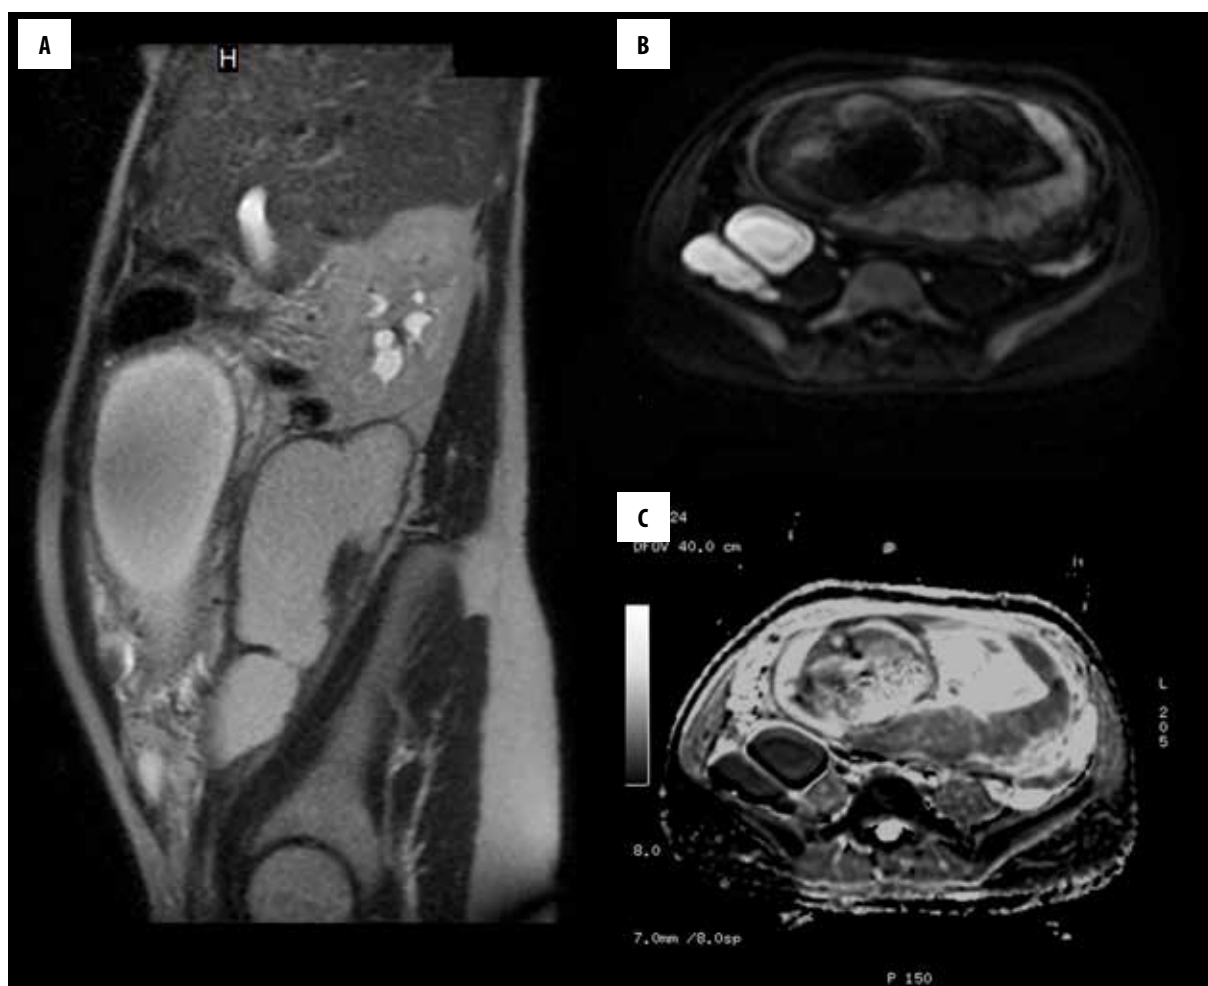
Abscess in the right iliopsoas muscle in a pregnant patient (week 33 of gestation). In a standard T2 sequence, it is seen as a fluid collection (A) with a high signal in DWI (B) and a black signal in ADC (C), which supports the diagnosis of an abscess.
